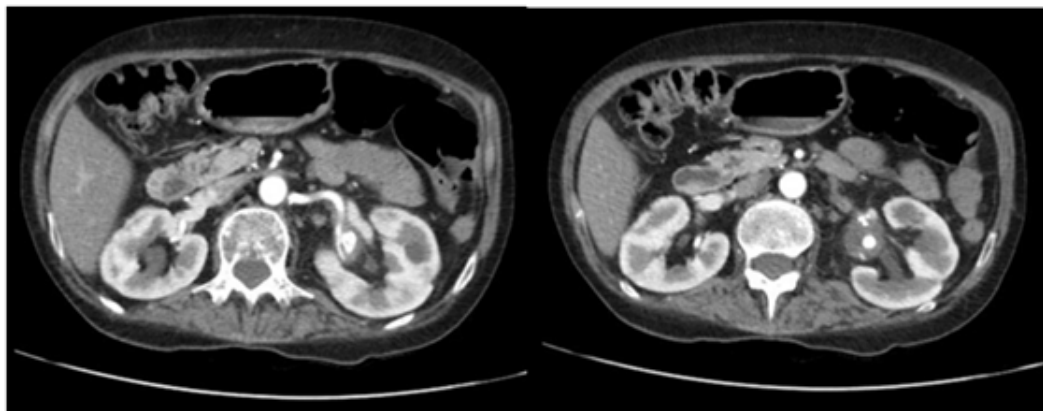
The CTA showing the mycotic aneurysm of the left renal artery.
